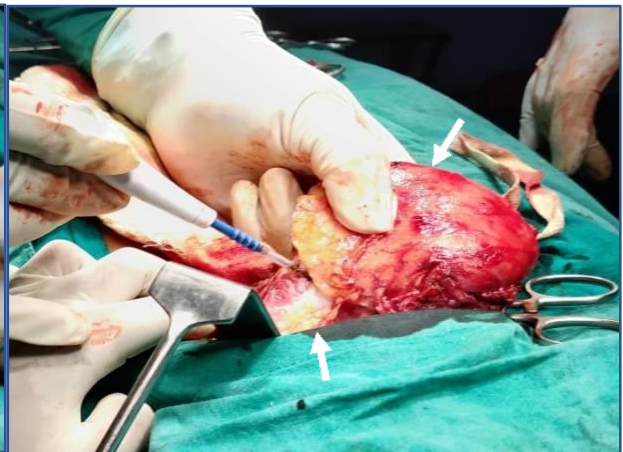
CT Abdomen Photograph showing a mass occupying left rectus sheath
